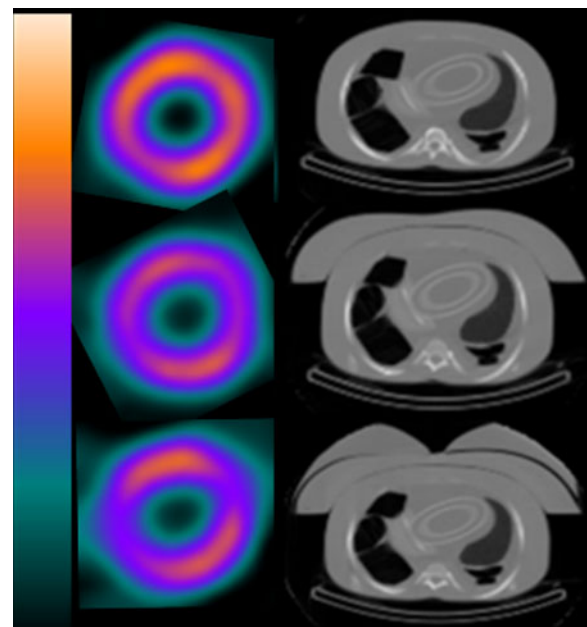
The short-axis slices (left column) and CT slices (right column) for the average male (upper), the large male (middle) and the large female (bottom), with no heart defects obtained at NGH. The additional attenuation material from the large male and large female reduced the counts in the inferoseptal and anterolateral myocardial wall. This effect is more pronounced for the large female.
